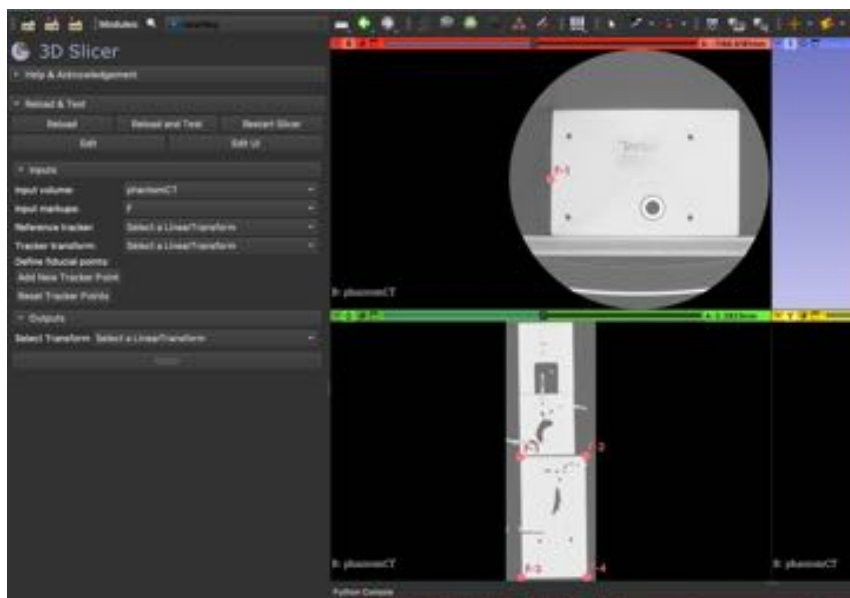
Module GUI for fiducial point registration showing markup points labeled on the CT volume
